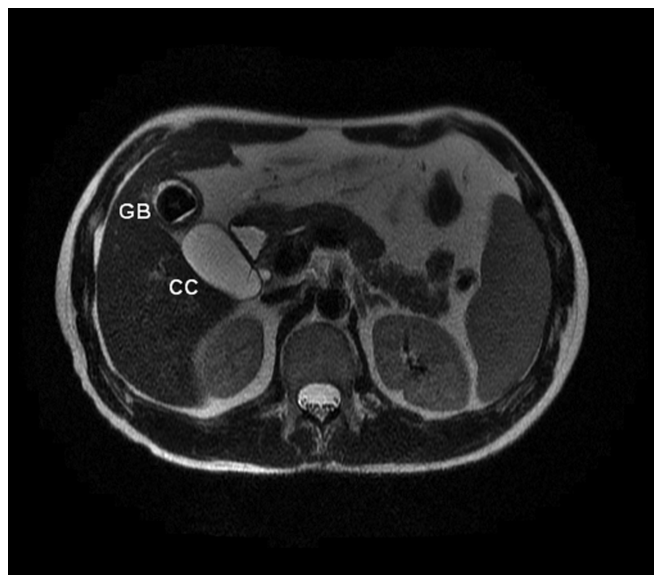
MRI (GB=gallbladder, CC=choledochal cyst).
